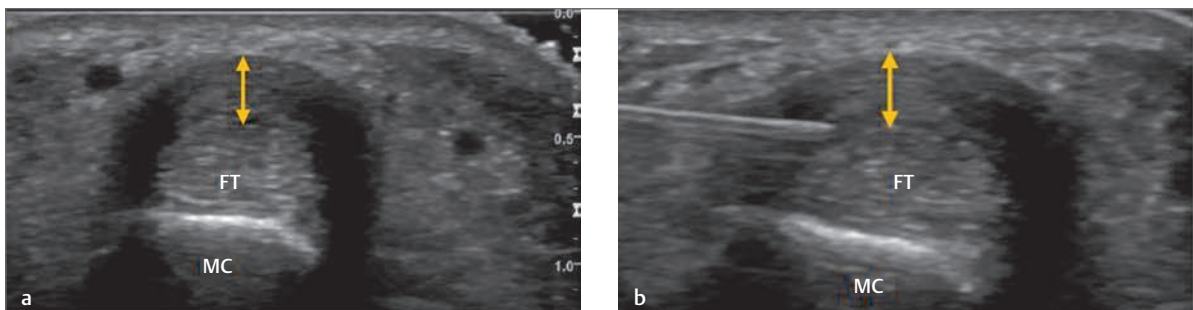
(a) Transverse image of the volar aspect of a ring finger at the level of the metacarpal head demonstrating marked thickening of the A1 pulley (*double-headed arrow*). (b) Transverse image of the volar aspect of an index finger at the level of the metacarpal head demonstrating thickening of the A1 pulley (*double-headed arrow*). A needle can be seen being placed between the flexor tendons and A1 pulley prior to injection. This image demonstrates the accuracy that is possible with ultrasound guided injection. FT, flexor tendons; MC, metacarpal head.
